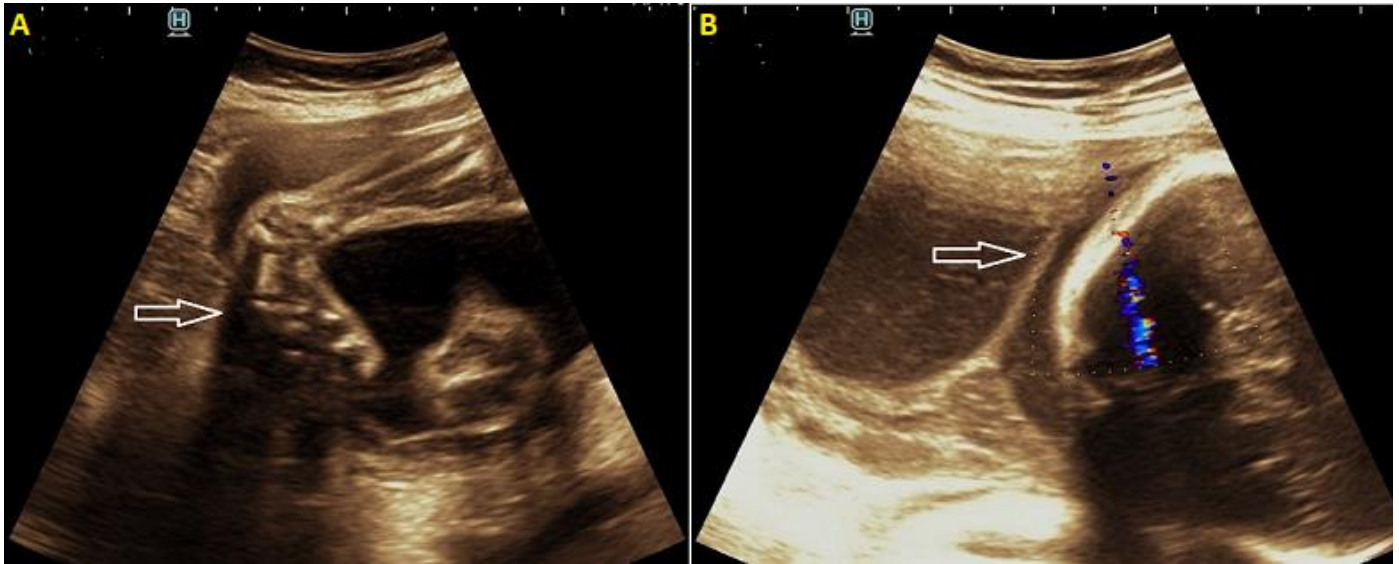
(A) ultrasound image showing medially rotated right foot suggesting club foot/CTEV; (B) ultrasound image showing a linear echogenic band at the lower end of uterus - amniotic band with an intact chorionic membrane
